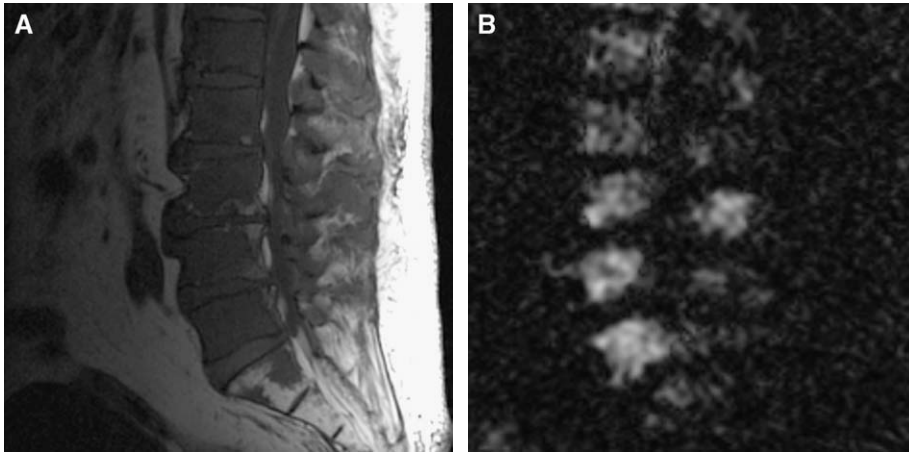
(A) Sagittal T1-weighted image in a prostate cancer patient shows diffuse metastases to all five lumbar and S1 vertebral bodies/posterior elements. (B) Sagittal diffusion-weighted imaging displays expected hyperintense signal intensity of the metastases within the affected vertebra.
